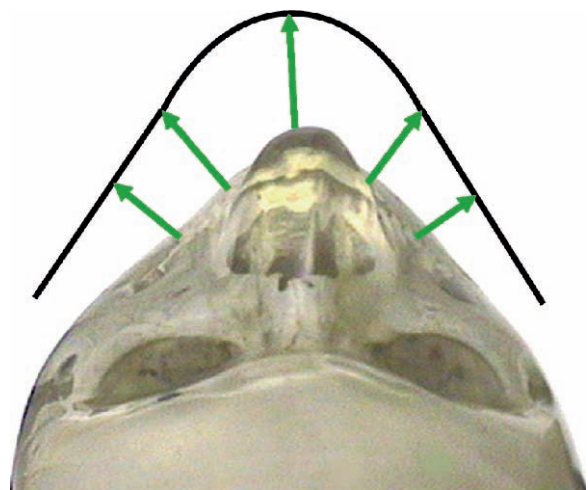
A panoramic radiograph simultaneously presents views from both sides of the patient's face as well as providing a frontal perspective
